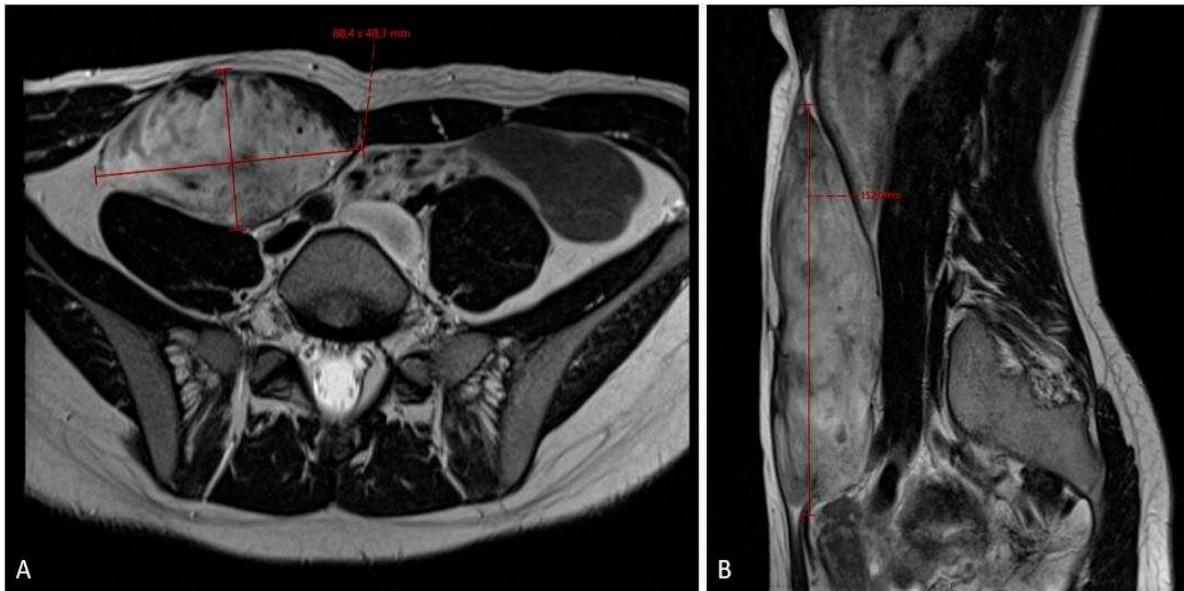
MRI scan (A – axial plane; B – sagittal plane) assessment of fibromatosis lesion at the first diagnostic scan sizing 8.8 x 4.8 x 15.3 cm.
